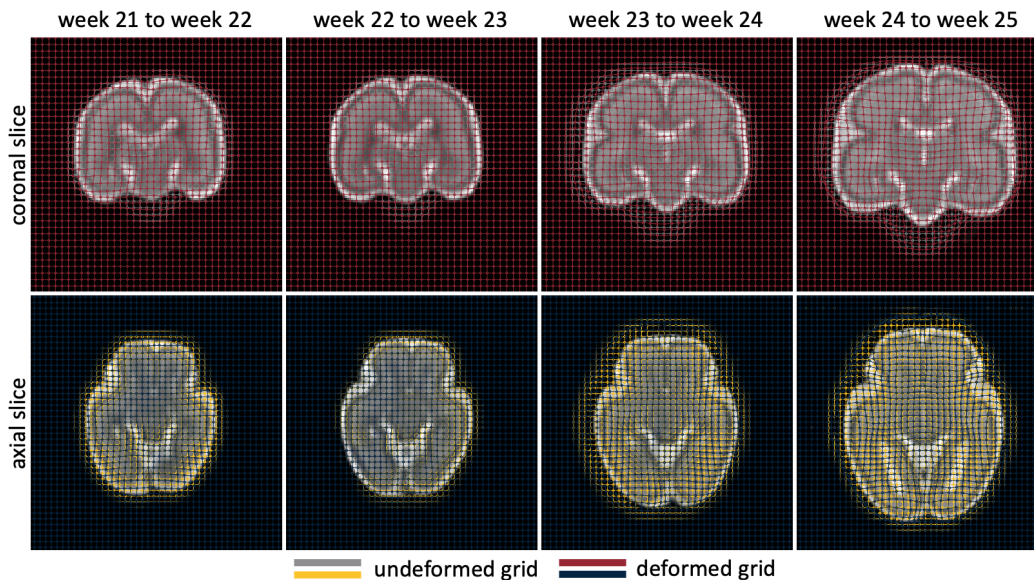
The registration framework iteratively updates the positions of control points that belong to the spline object embedded in each week’s MRI data. Here, we plot the undeformed and deformed grids in representative coronal and axial slices for the registrations between weeks 21 and 22, weeks 22 and 23, weeks 23 and 24 and weeks 24 and 25. From the MRI images we observe the overall volume increase of the brain during the 5 week period. The two grids per image show the increasingly heterogeneous displacement field with rather uniform morphogenetic growth between weeks 21 and 23 and more localized displacement patterns in individual lobes between weeks 23 and 25.
